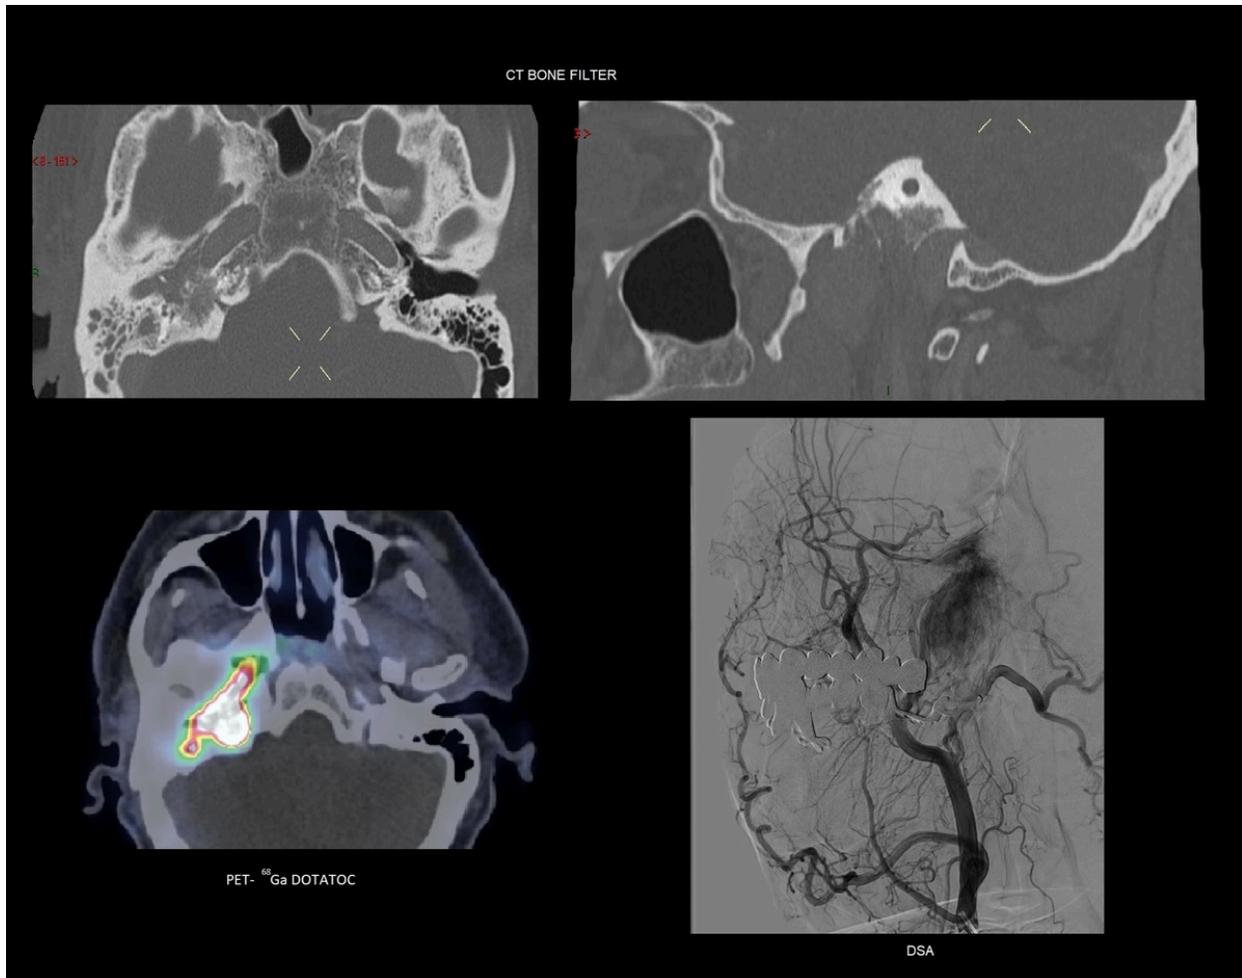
In the upper CT images, the same patient with a jugulotympanic paraganglioma determining the bone erosion of the temporal bone between the jugular and the carotid foramina. In the bottom left scan, PET-68Ga-DOTATOC\CT confirms that the resorption phenomena are partially due to the bone infiltration of the tumor. In the bottom-right corner, the image presents an angiogram of the right external carotid artery feeding the large hypervascularized mass of the paraganglioma.
